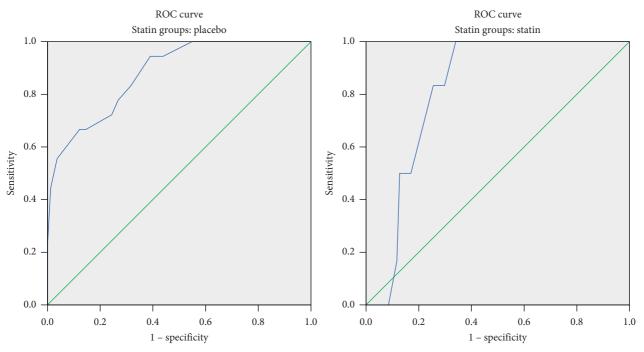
AUC regarding X-ray time of exposure.
